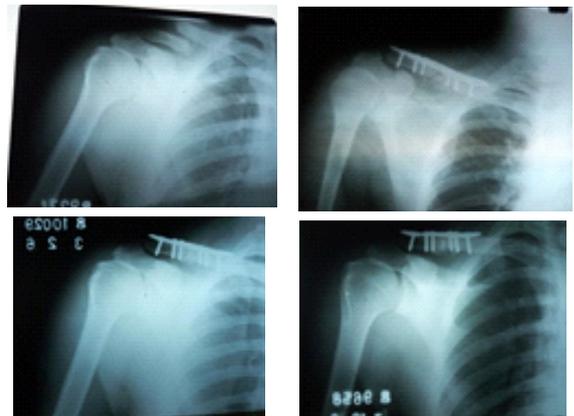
Pre-op Xray showing non-union. Fig 2:- Immediate post-op Xray Fig 3:- 6 weeks follow up Xray Fig 4:- 3 month follow up xray.
